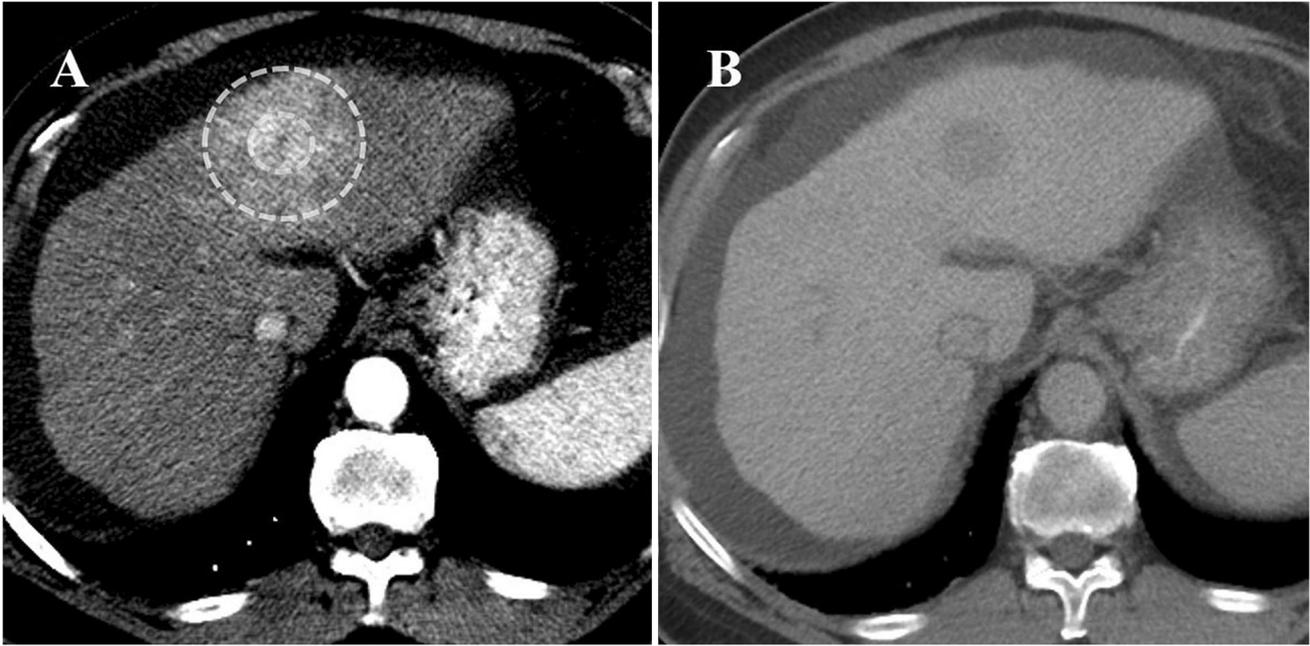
Contrast-enhanced CT shows the presence of a APHE observation on HAP (a) surrounded by corona enhancement (between the inner and outer circles). This
